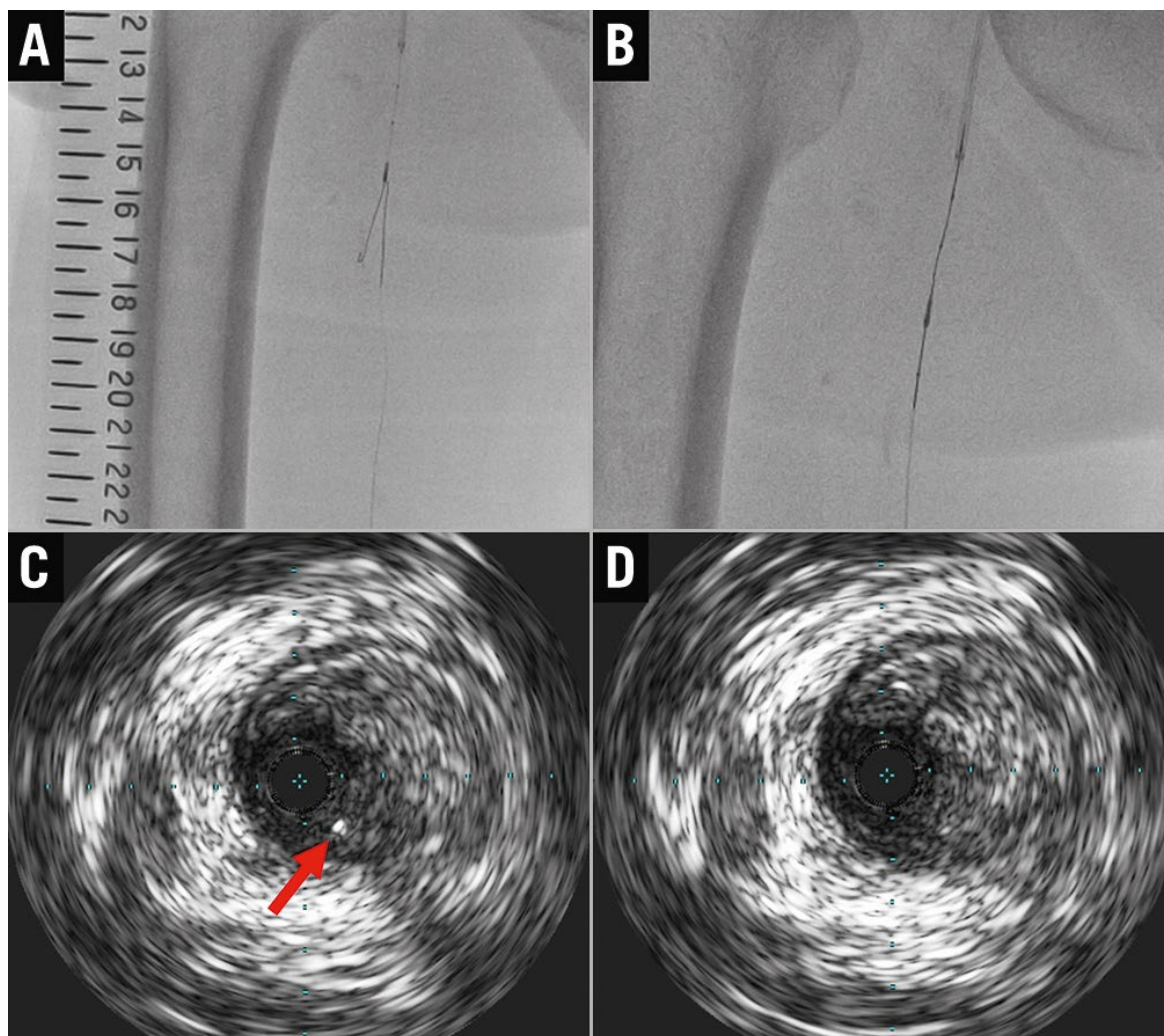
Intraluminal rendezvous imaging. A,B) Retrograde guidewire crossing and direct rendezvous into the wire lumen of the antegrade intravascular ultrasound (IVUS) catheter under real-time IVUS and (C,D) under fluoroscopic guidance. The red arrow indicates the guidewire.
